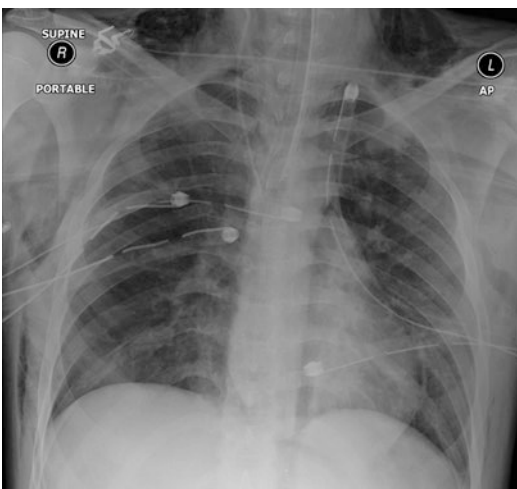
X-ray image of a chest showing parenchymal haemorrhage and pleural drains for treatment of the pneumothorax
